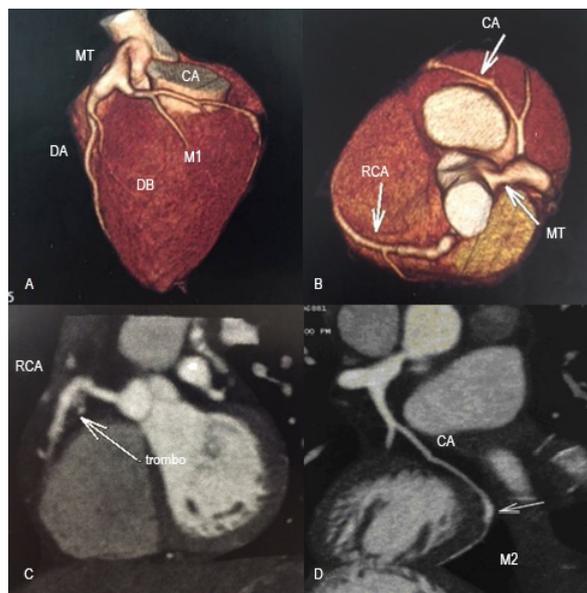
Coronary computed tomography angiography showed aneurysm at the distal third of the left coronary artery trunk (9mm) and anterior descending artery ostium (9.5 mm); circumflex artery with ectasia at the ostium (3.7 mm); marginal branch 2 with aneurysm at the distal segment; right coronary artery with saccular aneurysm (9.8 mm at the greatest diameter), mural thrombus and small regions of calcification. Total score of 23.81 (Agaston) and 38.59 (Volume). MT: main trunk of the left coronary artery; DA: anterior descending artery; DB: diagonal branch; CA: circumflex artery; M1: left marginal artery; M2: second marginal branch of circumflex artery; RCA: right coronary artery; LA: left atrium; Ao: aorta
